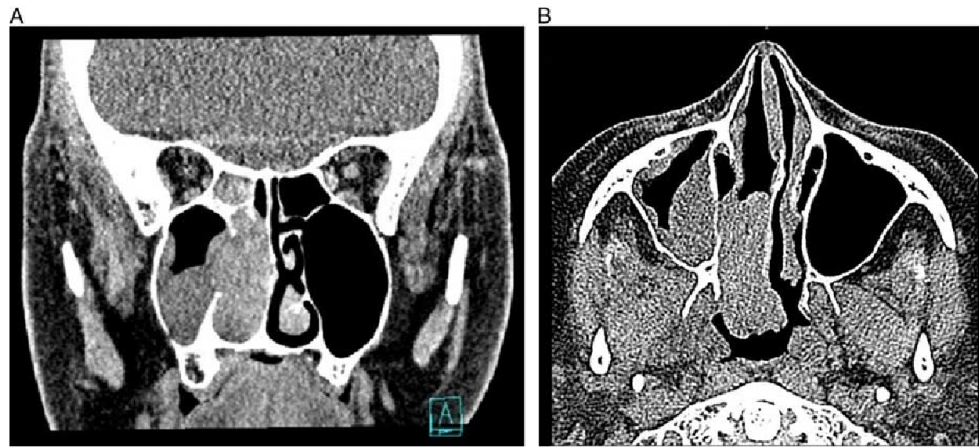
Representative imaging of case 2. A, Coronal computed tomography of case 2 demonstrating a right-sided nasal mass. B, The mass extends into the nasopharynx. There was no involvement of the maxillary sinus.
